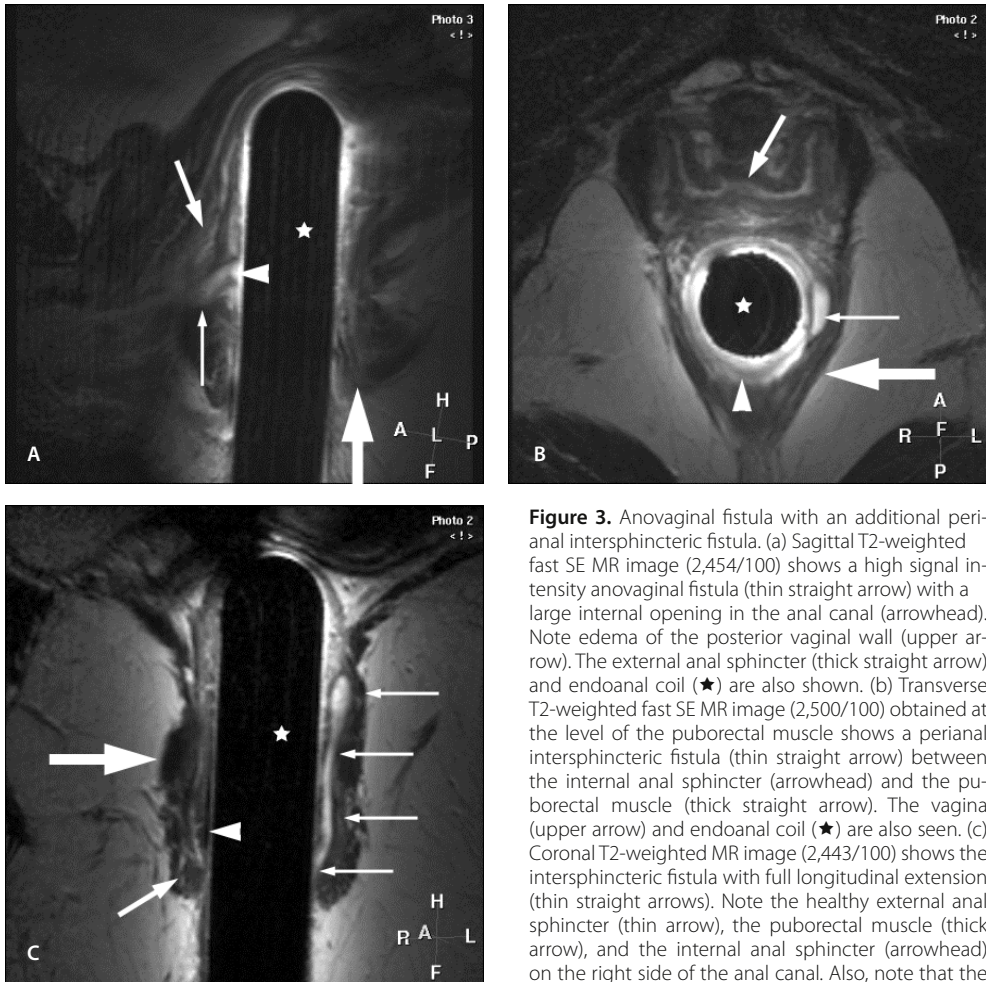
Anovaginal fistula with an additional perianal intersphincteric fistula. (a) Sagittal T2-weighted fast SE MR image (2,454/100) shows a high signal intensity anovaginal fistula (thin straight arrow) with a large internal opening in the anal canal (arrowhead). Note edema of the posterior vaginal wall (upper arrow). The external anal sphincter (thick straight arrow) and endoanal coil (★) are also shown. (b) Transverse T2-weighted fast SE MR image (2,500/100) obtained at the level of the puborectal muscle shows a perianal intersphincteric fistula (thin straight arrow) between the internal anal sphincter (arrowhead) and the puborectal muscle (thick straight arrow). The vagina (upper arrow) and endoanal coil (★) are also seen. (c) Coronal T2-weighted MR image (2,443/100) shows the intersphincteric fistula with full longitudinal extension (thin straight arrows). Note the healthy external anal sphincter (thin arrow), the puborectal muscle (thick arrow), and the internal anal sphincter (arrowhead) on the right side of the anal canal. Also, note that the internal sphincter on the left side of the anal canal is
